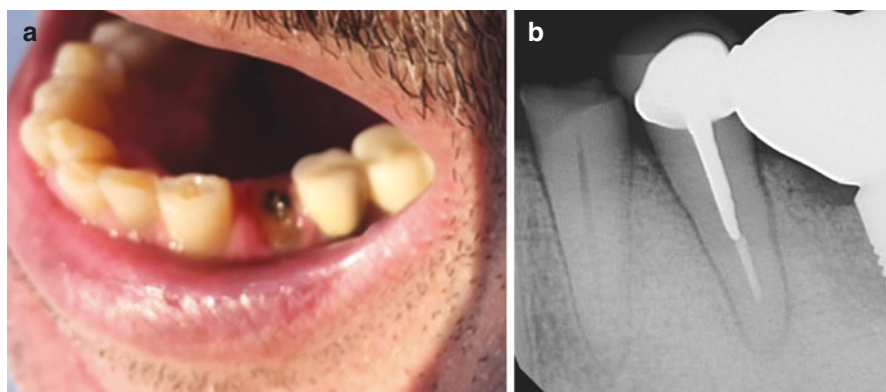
Clinical and radiograph of a failing bicuspid indicated for extraction. Although there is only a single conical root, the proximity to other potentially failing and overhanging prosthesis complicates this case
